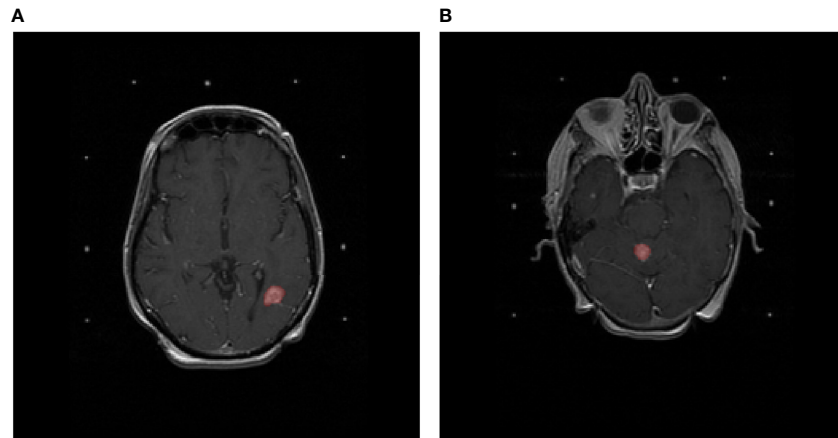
T1-weighted gadolinium-enhanced MRIs of the brain. Delineated in red (A) is a lesion that developed adverse radiation effects after stereotactic radiotherapy and (B) a lesion that did not develop adverse radiation effects after stereotactic radiotherapy.
